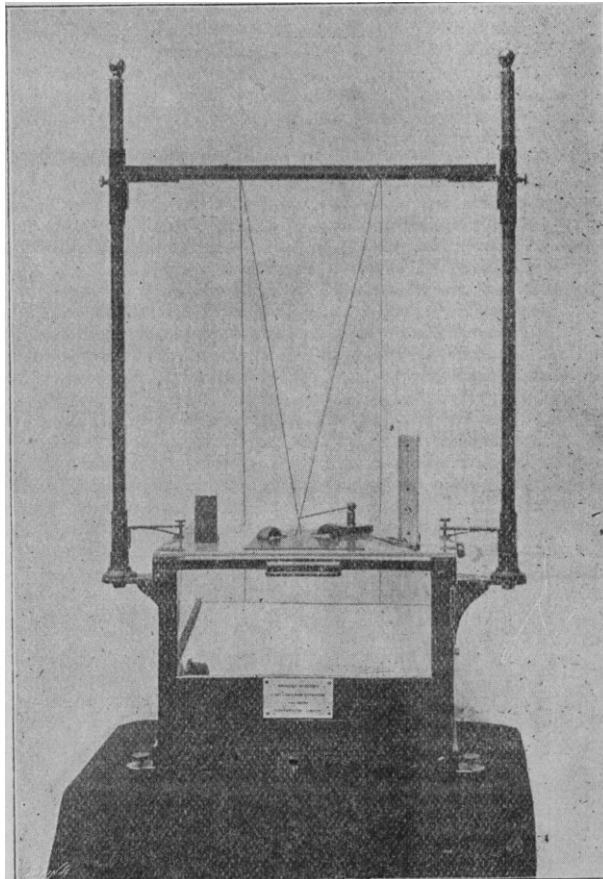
Davidson's localizer with threads projecting from the two distinct exposure positions of the x-ray focus to the radiographic film. Reproduced with the publisher's permission from the original work by Stanley Davidson (1898).
